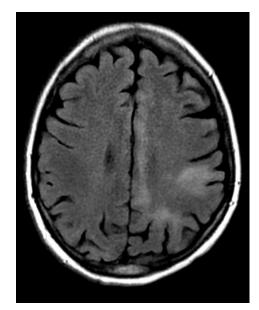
First brain MRI showed subcortical left parietal white matter lesion.
